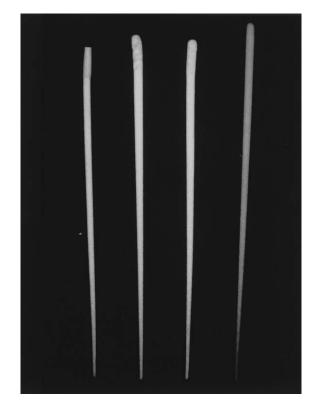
Radiographic comparison of gutta percha cones size 30, 0.02 taper from the following brands: Hygenic (*far left*), Caulk Densply ISO color (*middle left*), Caulk Densply ISO noncolor (*middle right*), and MicroSeal (*far right*).
